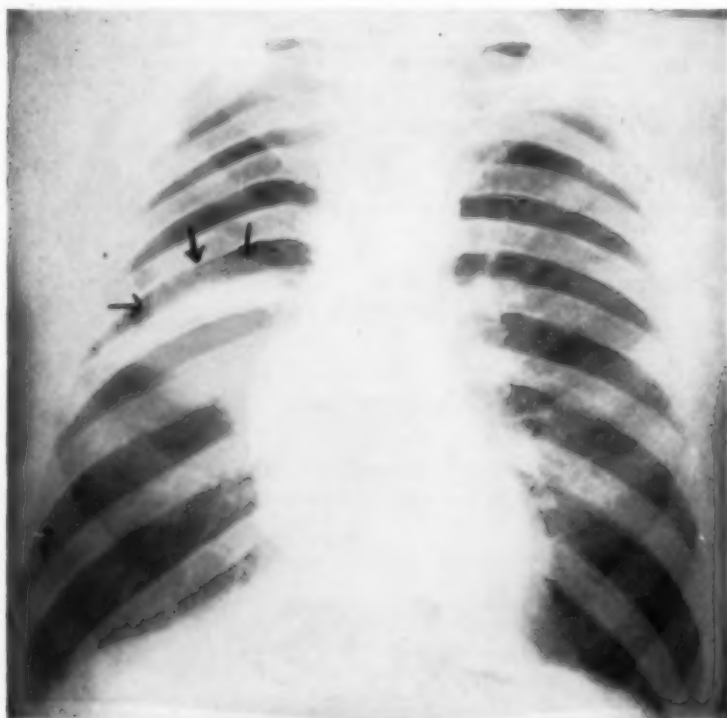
Chest roentgenogram visualizes selective pneumothorax with complete collapse of the right upper lobe.
